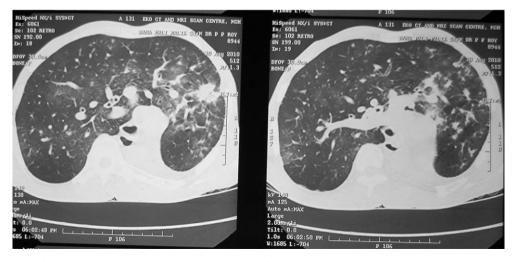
Parenchymal window of contrast enhanced CT scan chest showing absence of left lung and herniation of right lung to the left, also there are bronchiectatic changes.
